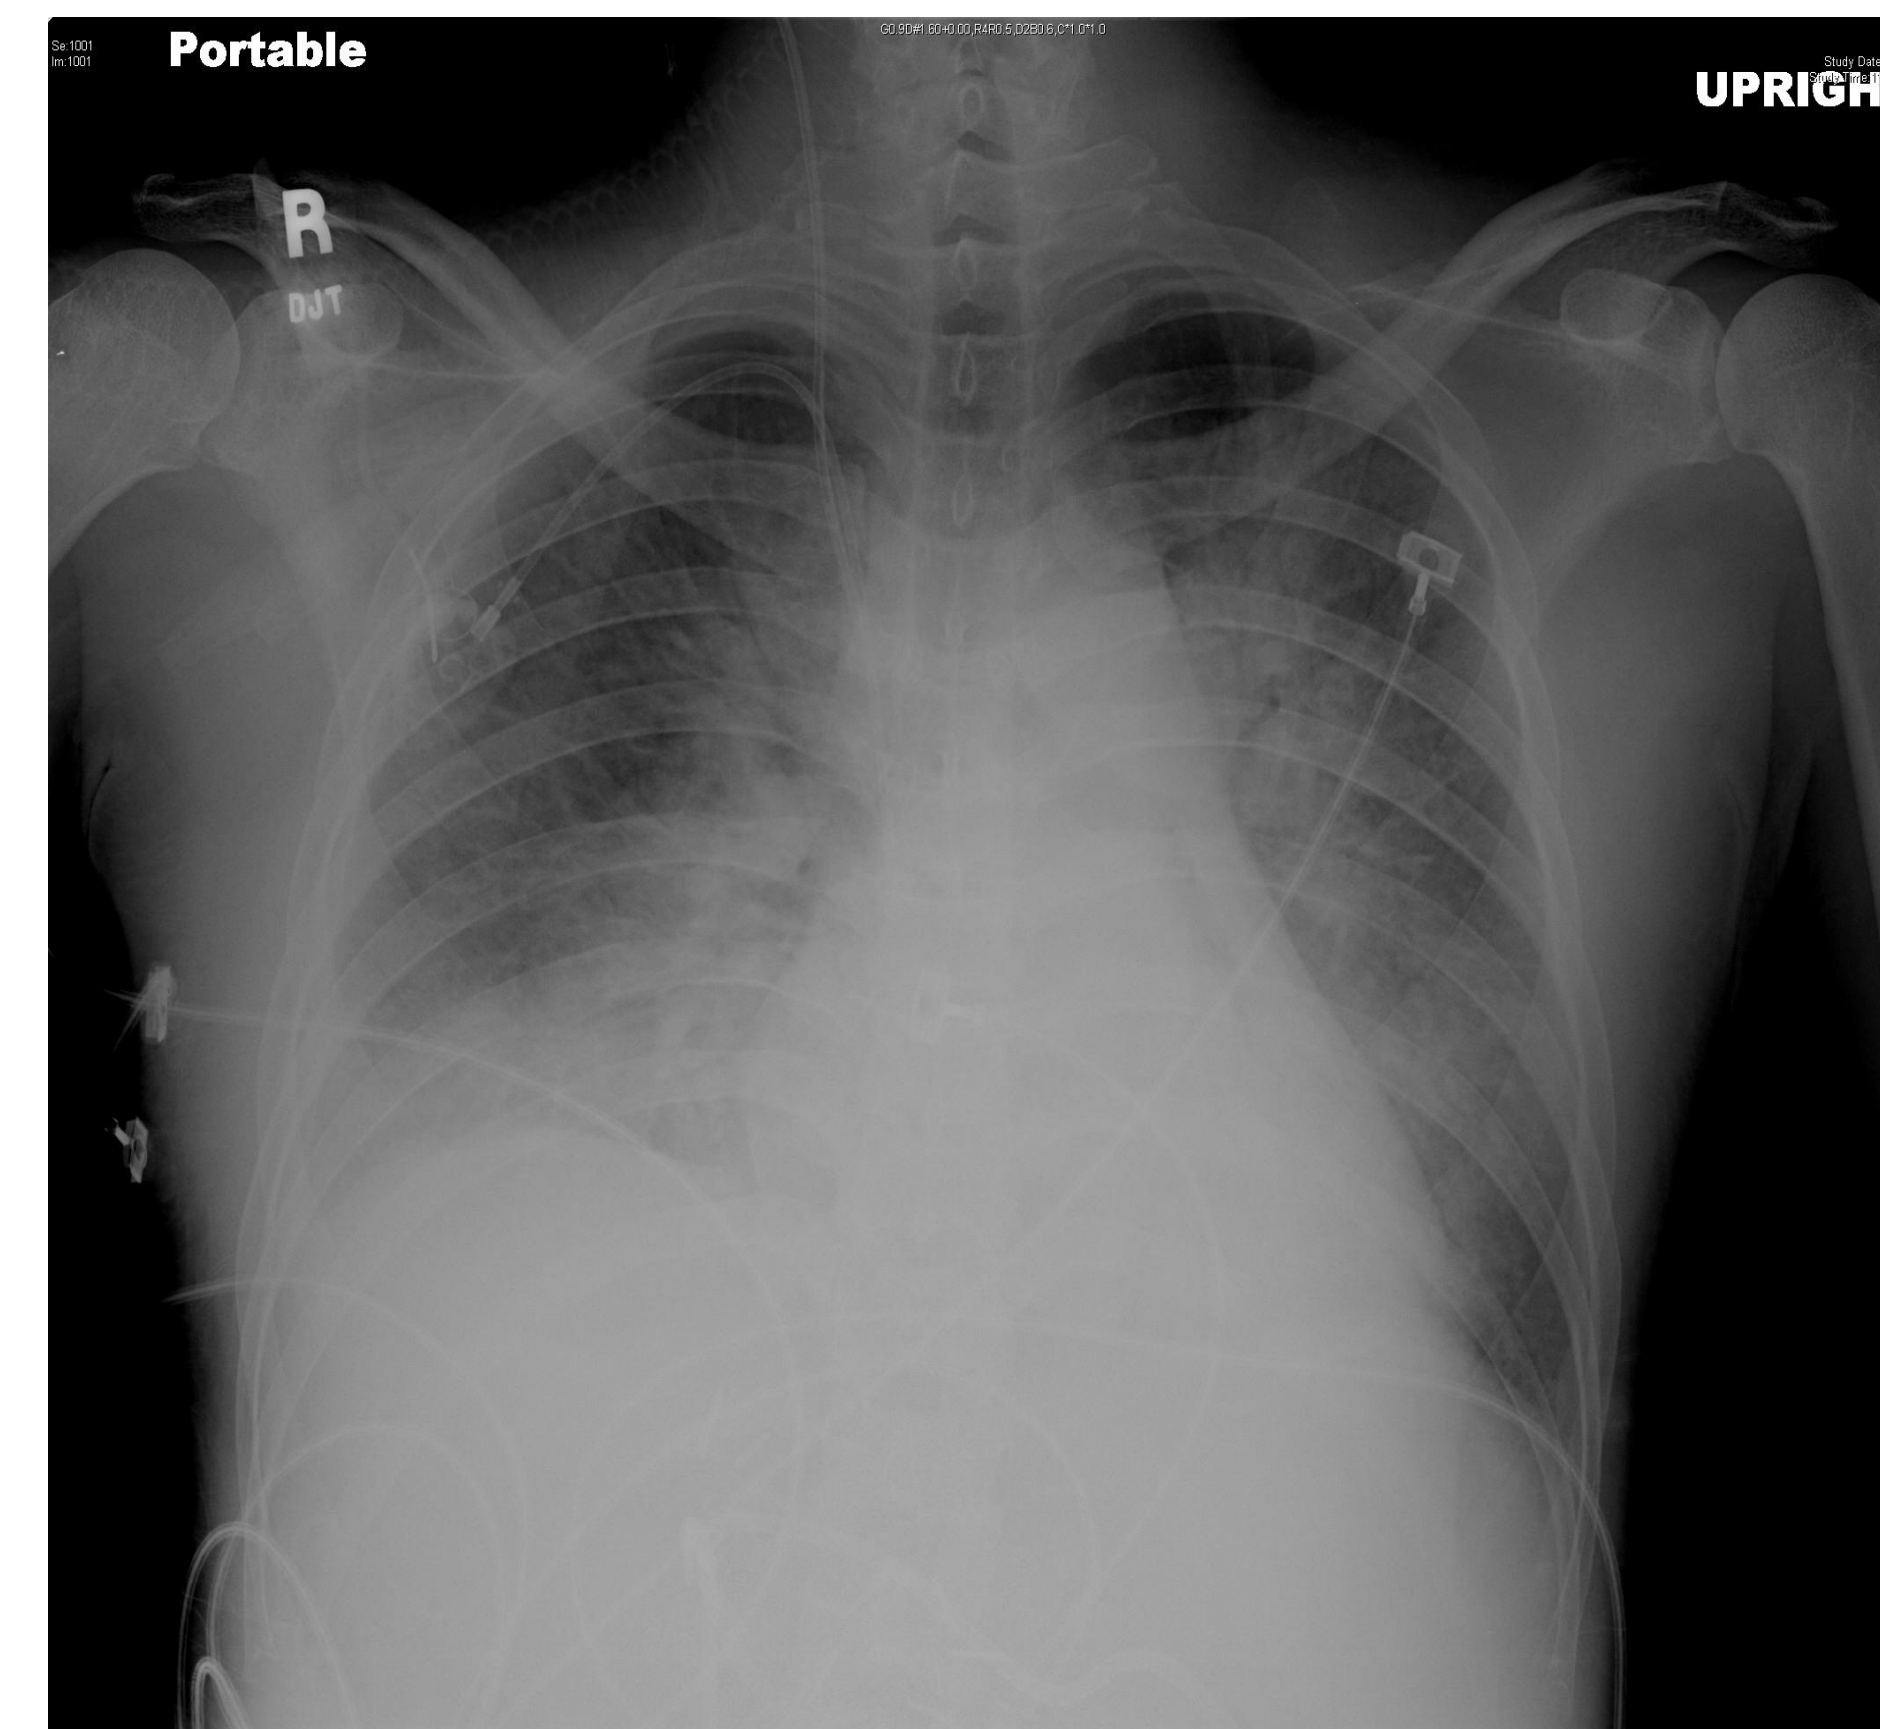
Chest radiograph four hours after admission, post-procedure. Note the bilateral patchy infiltrates, evidence of airway disease.
